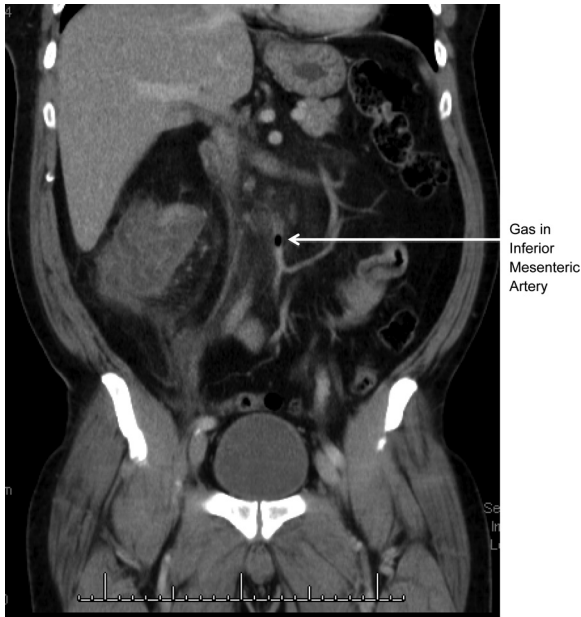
Preoperative computed tomography (CT) scan of *Clostridium septicum* aortitis showing free air in inferior mesenteric artery on coronal section.
